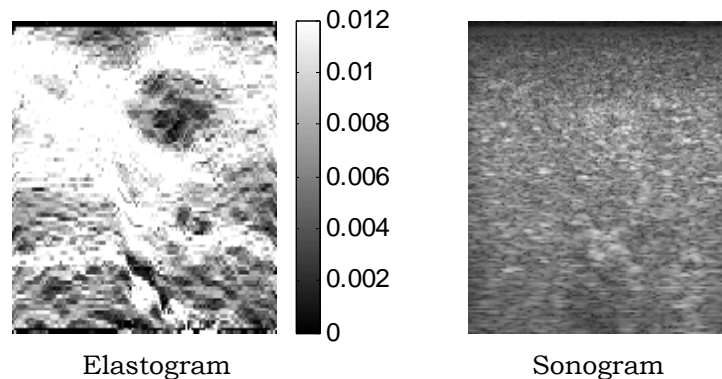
In vivo* elastogram (left) and sonogram (right) of an induced hepatic lesion (1.0 mL ethanol dose injected at a depth of 12 mm). Dark regions in the elastogram indicate stiff tissue as compared to the soft background.
